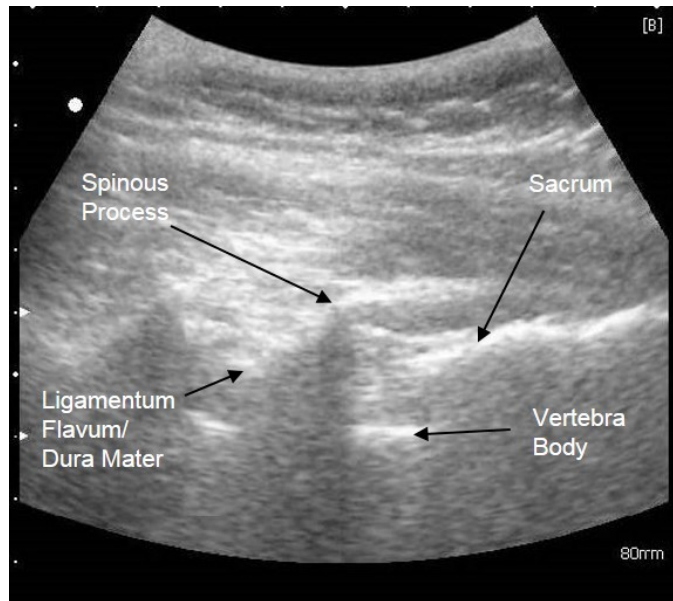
Ultrasound Image Feature in the Longitudinal View.
